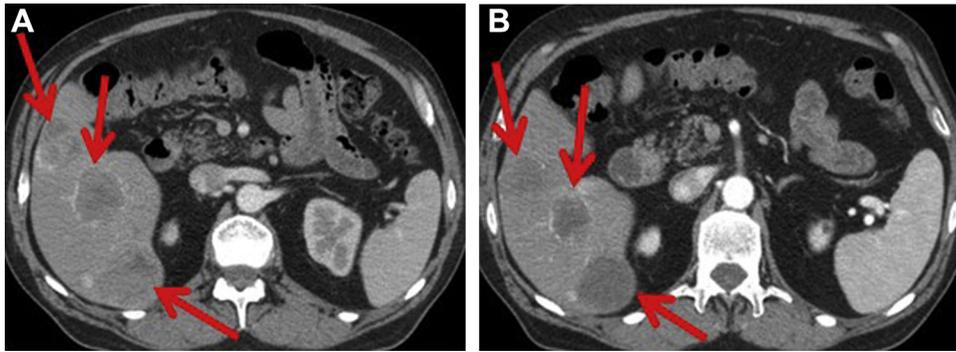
Patient with neuroendocrine tumor and carcinoid syndrome. Pretreatment (A): Patient with low-grade metastatic neuroendocrine tumor and refractory carcinoid syndrome. Contrast-enhanced CT scan demonstrates numerous hypervascular metastatic lesions in the right liver (red arrows). Posttreatment (B): Patient with low-grade metastatic neuroendocrine tumor and refractory carcinoid syndrome—6 months after treatment. Contrast-enhanced CT scan demonstrates the metastatic lesions in the right liver (red arrows) have decreased in size and vascularity compared with pretreatment images.
